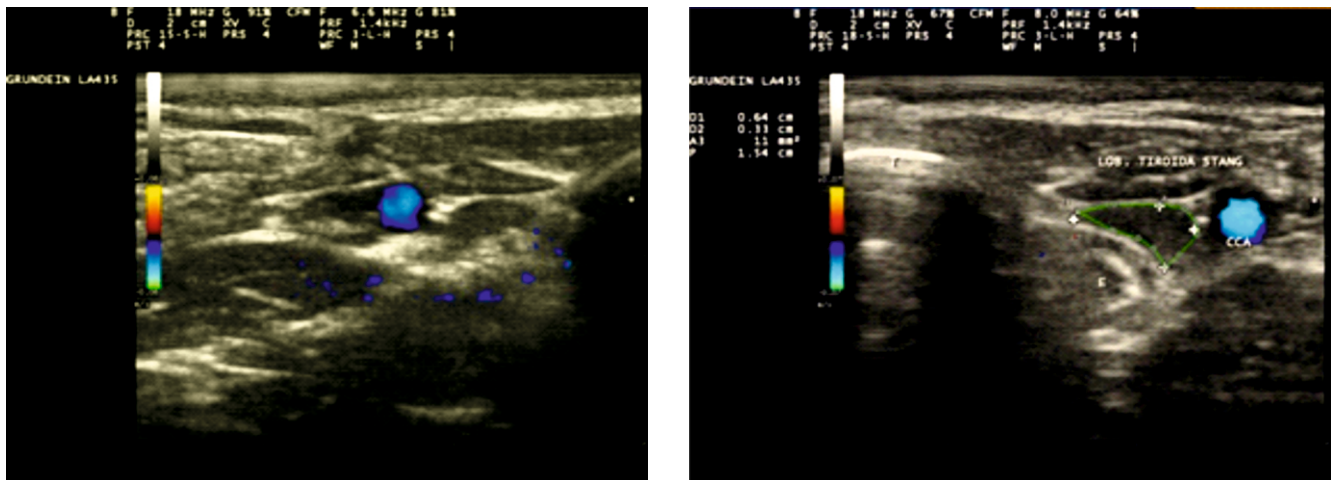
Transverse Color Doppler mode images
